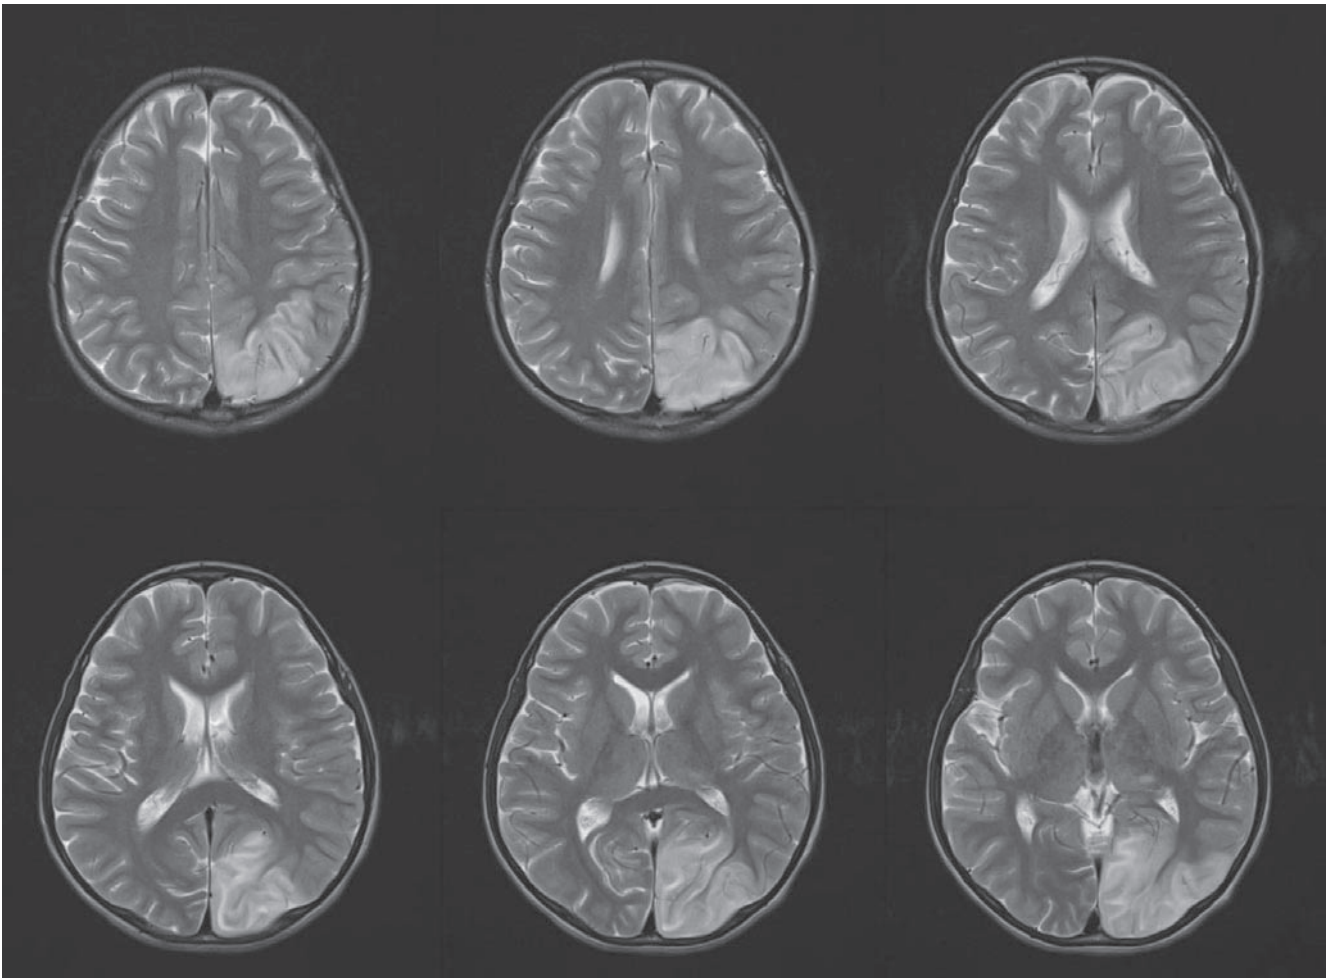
Magnetic resonance imaging showing gyral swelling with T2-hyperintensity over left posterior parietal and left occipital regions. Involved gyri show hyperintense signal on diffusion weighted imaging and hyperintense-to-isointense signal on ADC map.
